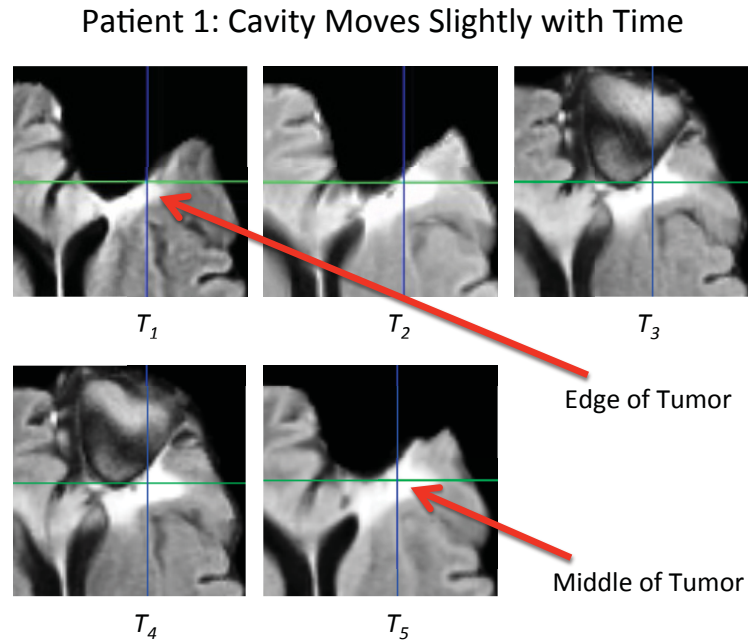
Patient 1 resection cavity movement shown by five post-operative non-linearly registered FLAIR MRIs. The cross hairs show the same coordinates in each image.  $FLAIR_3$  and  $FLAIR_4$  have some CSF artifacts in the resection cavity that can be ignored according to our collaborating neurosurgeon.
